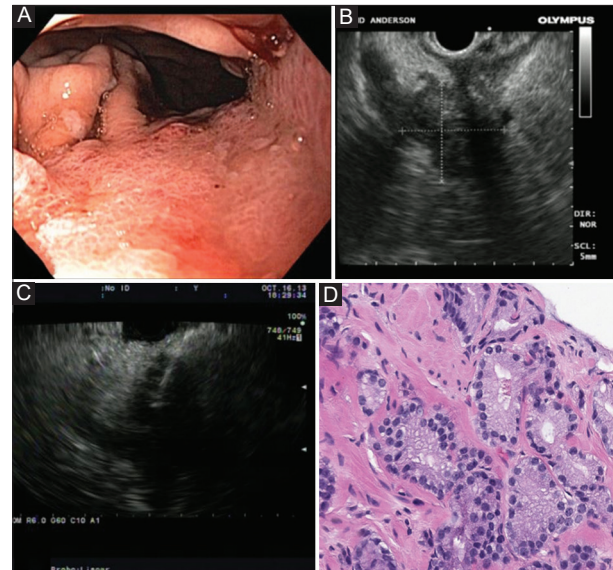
(A) Endoscopic view of depressed area within proximal gastric body. (B) Endo-ultrasonographic view of pancreatic mass extending to the stomach. (C) Ultrasonography-guided fine-needle aspiration (yellow arrow) of pancreatic head mass. (D) Cytopathology slide of pancreatic adenocarcinoma at 200× total magnification
